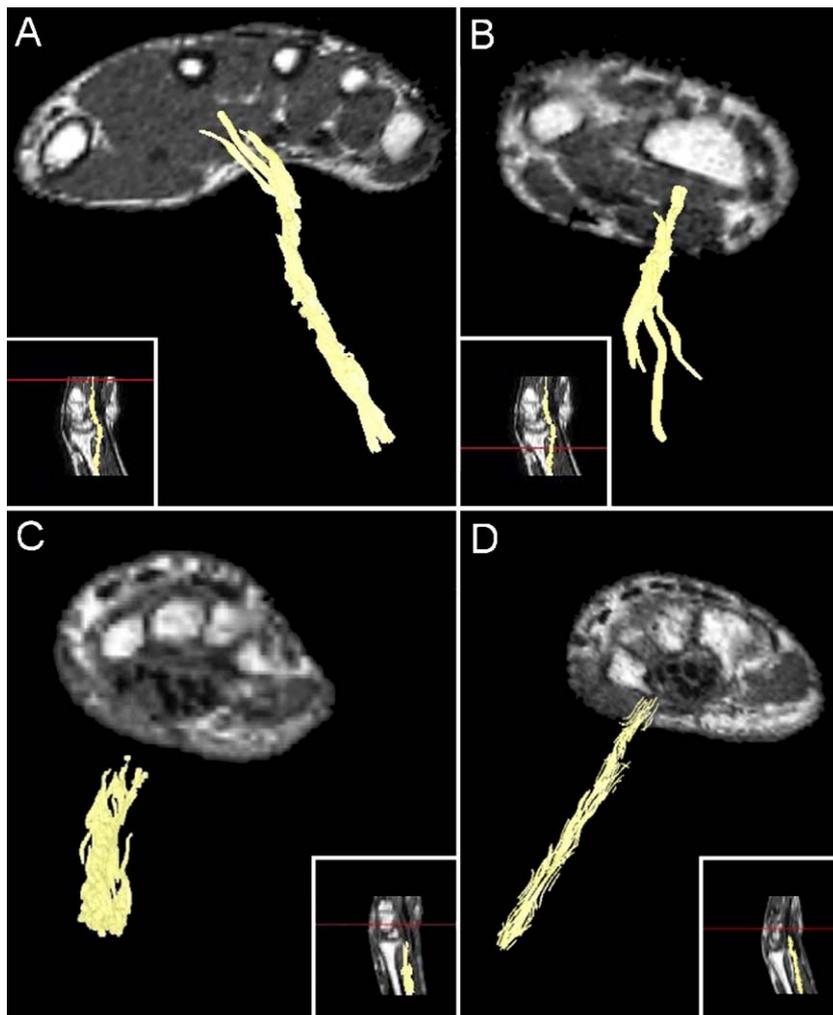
Diffusion tensor images (A) in black and white, a view from proximal to distal on a T1-weighted slice through the metacarpals. The exact anatomical location of the slice can be seen in the inset (red line). Bottom is proximal, and top is distal. Perpendicular to this slice is a 3D over-projection of the fiber obtained by fiber tracking (yellow structure). (B) The same right wrist as in panel A but now a distal to proximal view on a slice through the distal radius and ulna. (C) One month postoperatively images of the patient with the right median nerve lesion. The T1-weighted slice is through the carpus, seen from proximal. The inset also shows where the fiber tracking of the median nerve stops. (D) The same patient, 2 months postoperatively. The fiber can be tracked more distal than 1 month earlier.
